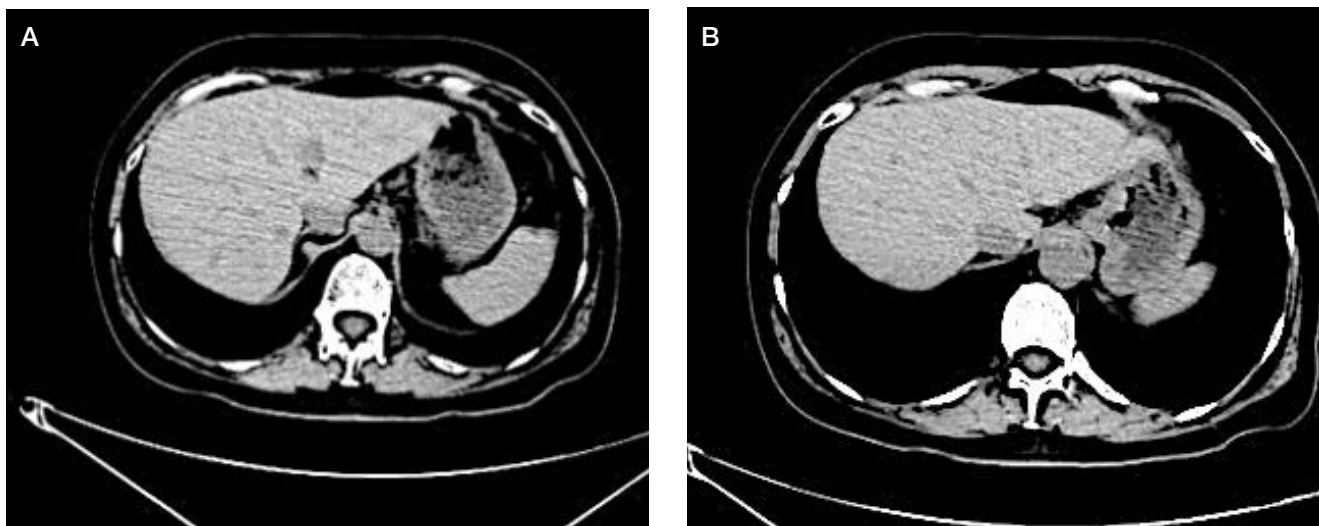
A, B. Abdominal CT, 04.05.2022. Multiple metastatic foci (size up to 2.6 cm) in both lobes, uneven opacification; no changes since December 2021
